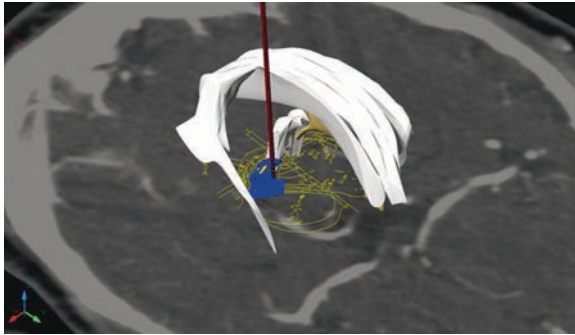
Three-dimensional reconstruction of the PPN, pars disseminata (*blue*) and pars compacta (*yellow*) with representation of the lead trajectory (*dark red*). Note the lamina quadrigemina (*white*) and the third ventricle (*light brown*). Background: axial slide of angio-CT scan with overlying 2D slides from Schaltenbrand–Wahren brain atlas (Tc 0, Tc -3)
